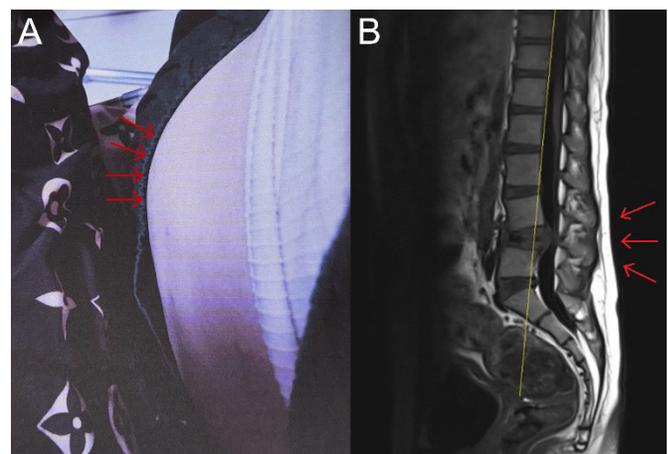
Clinical photograph of a 15-year-old girl demonstrating deformity changes in the lumbar region following tuberculous spondylitis. B. Sagittal MRI of the same patient showing destruction of the L4 vertebrae and retrolisthesis of the L3 vertebral body relative to L4.
